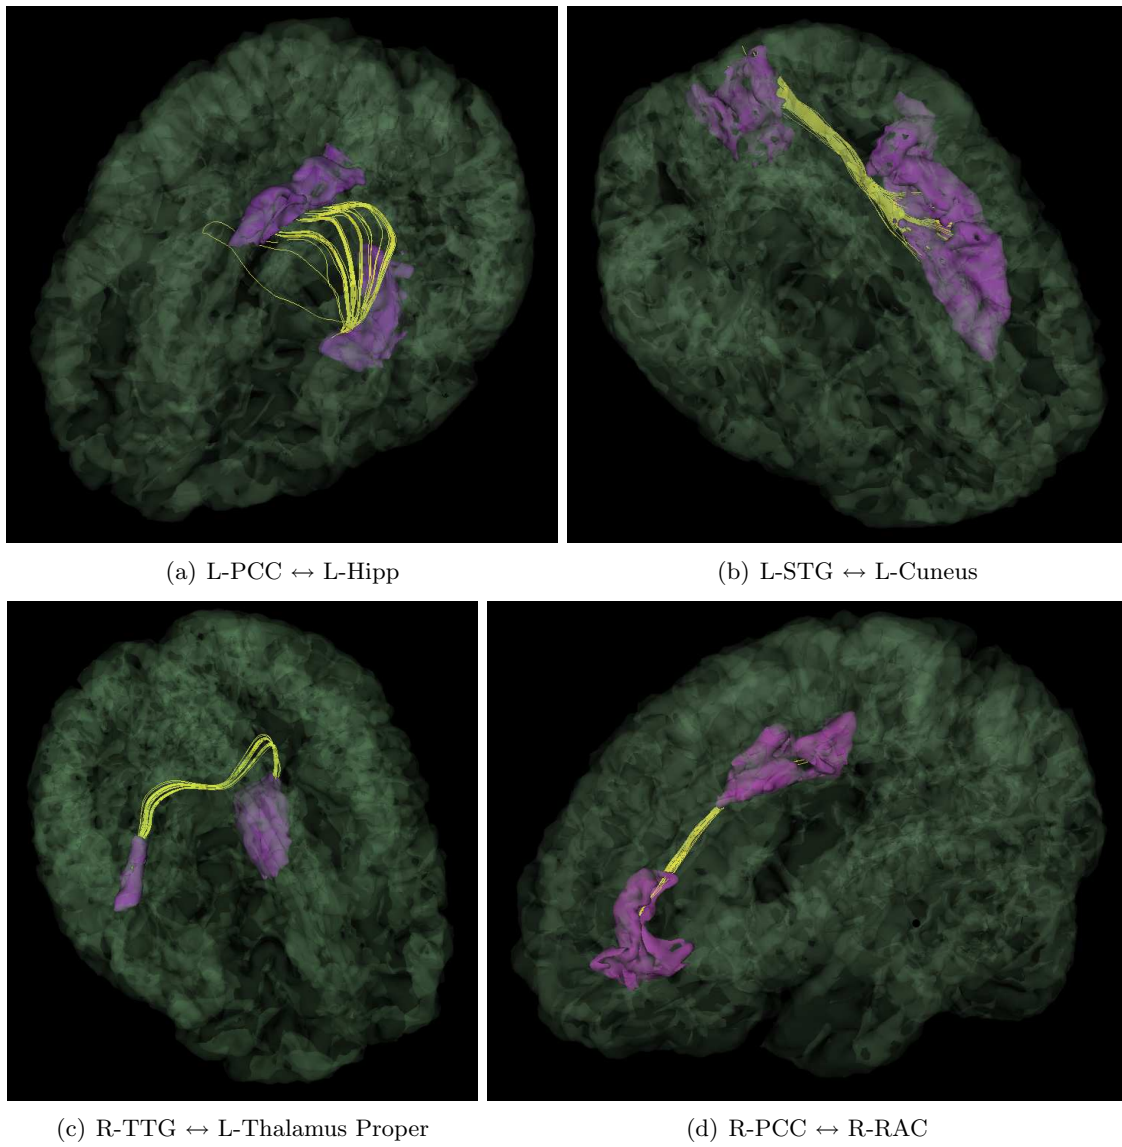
Representative DWI fibers for each of the significant anatomical connections identified by the joint model in Table 3.3. The corresponding ROIs are displayed in pink; the fibers are depicted in yellow.
